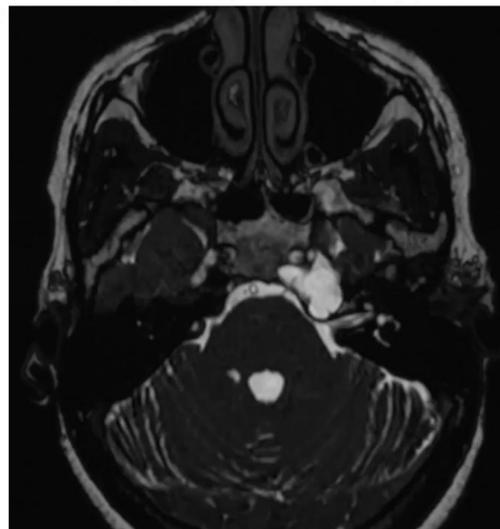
MRI demonstrated left petrous apex lesion with flair hyperintensity and intrinsic T1/T2 hyperintensity and lack of enhancement.
